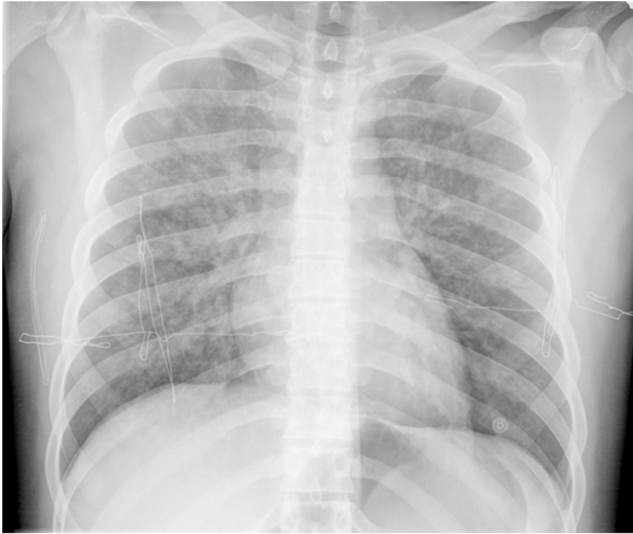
Chest radiography shows bilateral diffuse pulmonary infiltrates consistent with pulmonary edema. The cardiac size is within normal.
